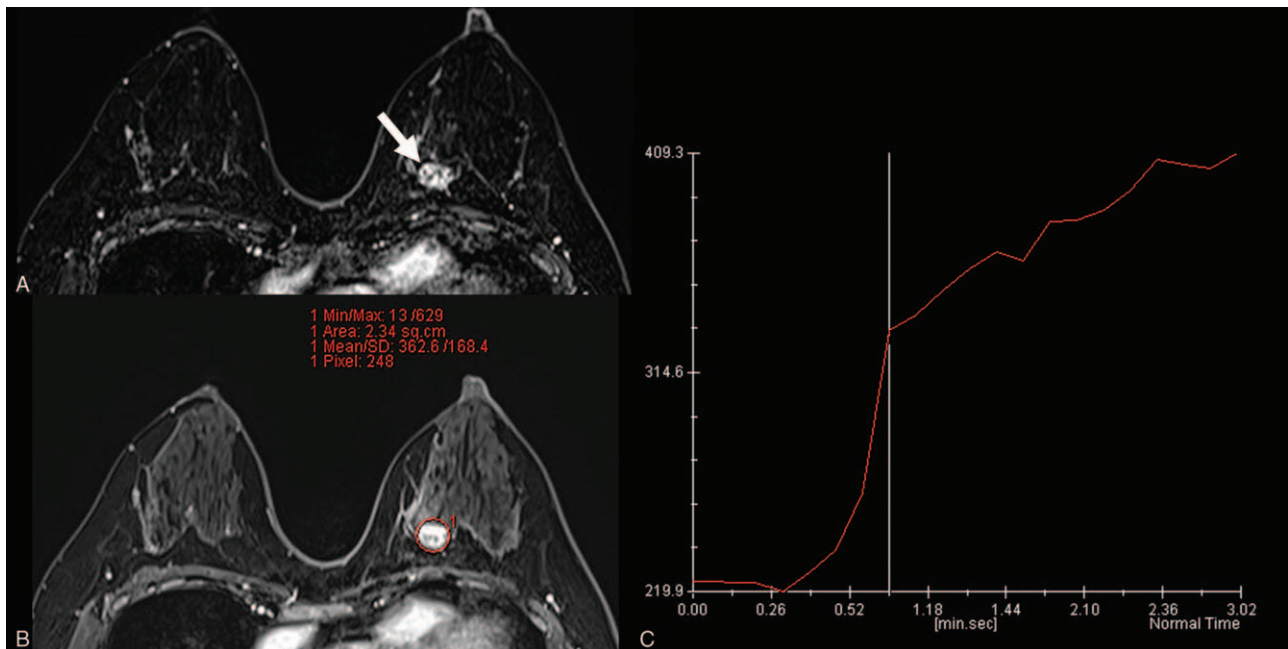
An invasive breast cancer in the left breast of a 49-year-old woman. (A) The combined abbreviated-ultrafast MRI phase using TWIST revealed an invasive breast cancer (showed by arrow). (B) The regions of interest were demarcated on the invasive cancer. (C) Relative enhancement vs. time curve derived from the combined abbreviated-ultrafast MRI phase using TWIST image.
